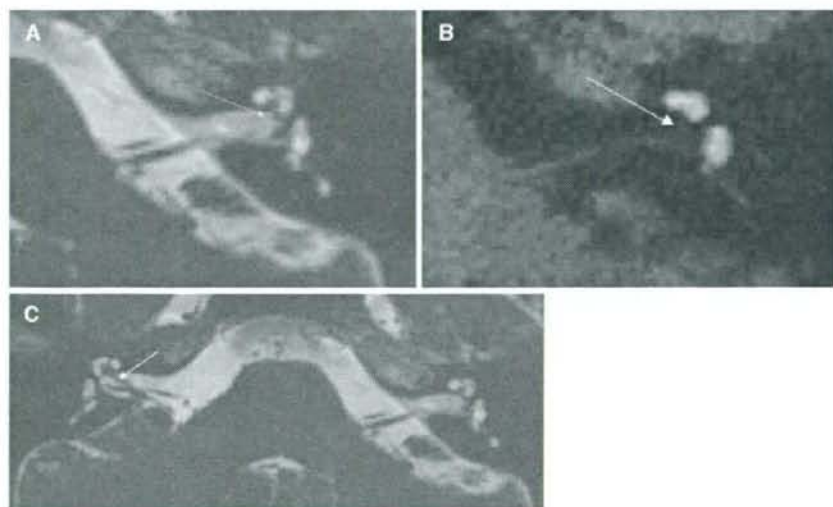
A 43-year-old woman had Meniere's disease. The singular canal is visualized on computed tomography (CT) (A, arrow) and 3D-CISS (B, arrow). C No enhancement is seen on 3D-FLAIR (arrow), whereas the vestibule is enhanced
